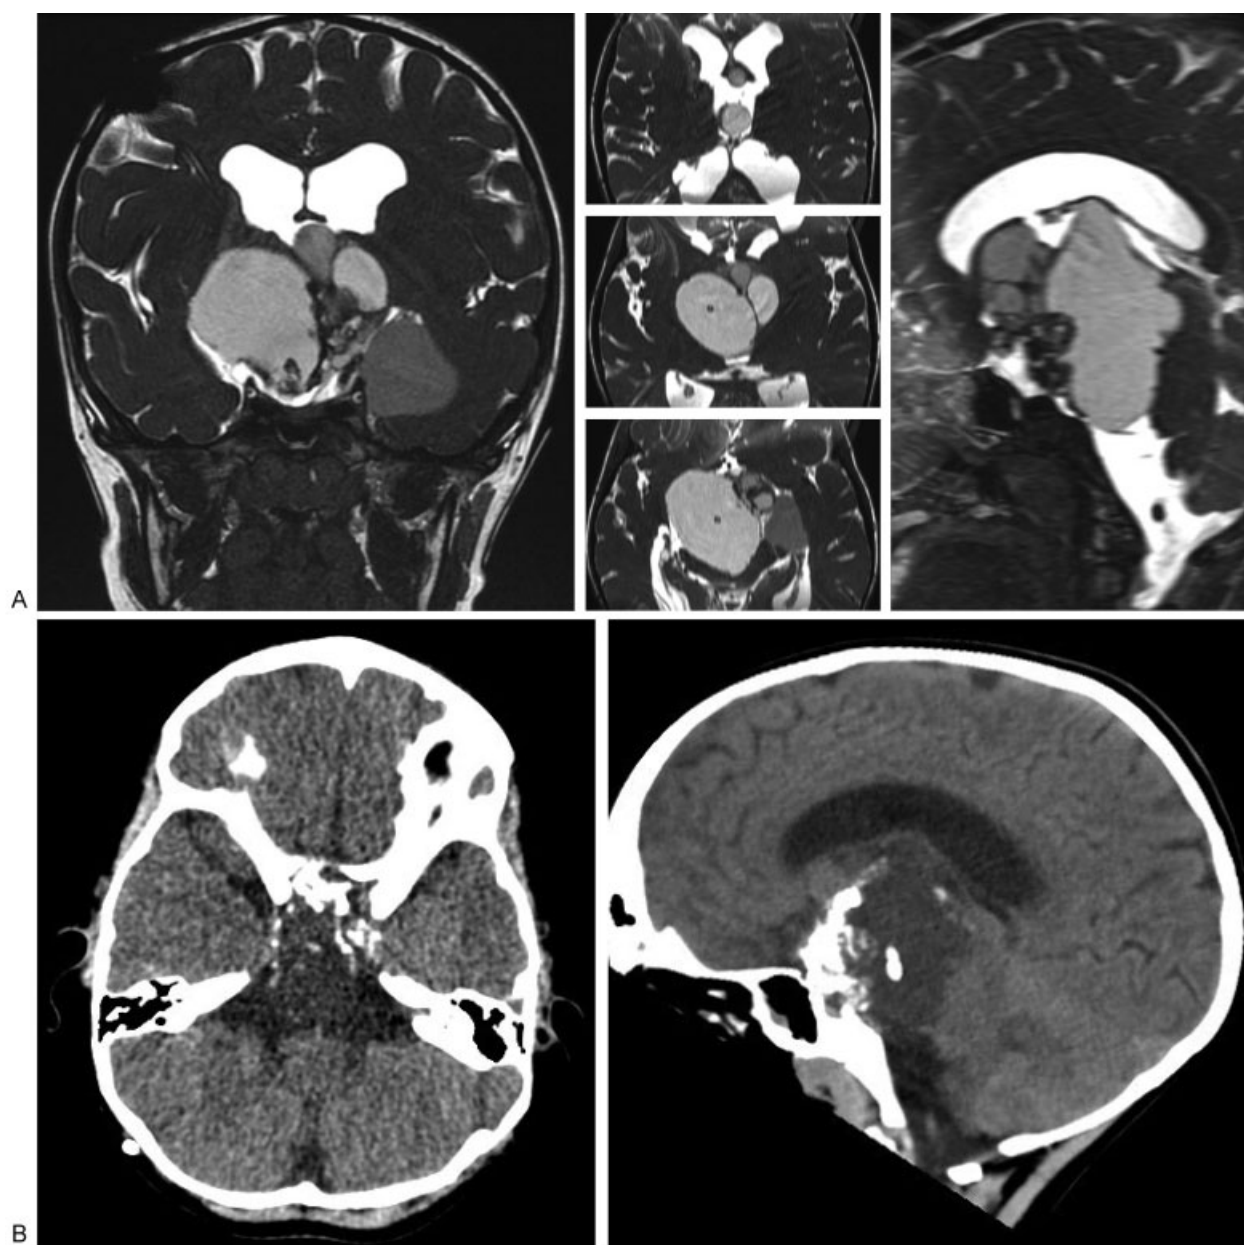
T2-weighted magnetic resonance imaging of the brain in the coronal, axial, and sagittal planes (A) demonstrates a complex, polycystic, mixed density mass centered about the sella, with significant extension into the third and lateral ventricles, interpeduncular and prepontine cisterns, and temporal lobe, as well as presence of a highly compressed cavum septum pellucidum, and a right frontal cystoperitoneal shunt. Nonenhanced head computed tomography demonstrates robust and diffuse calcification of the sellar and parasellar mass (B), diagnostic of craniopharyngioma in a pediatric patient.
